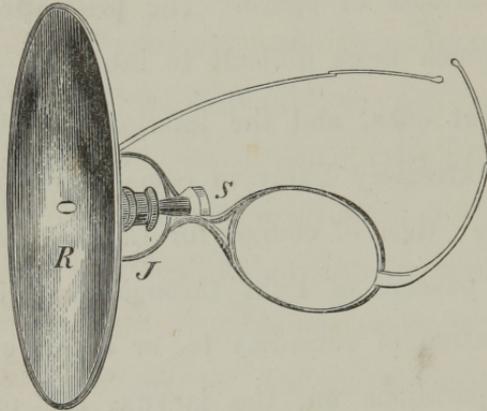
REFLECTOR ATTACHED TO SPECTACLE-FRAME.
